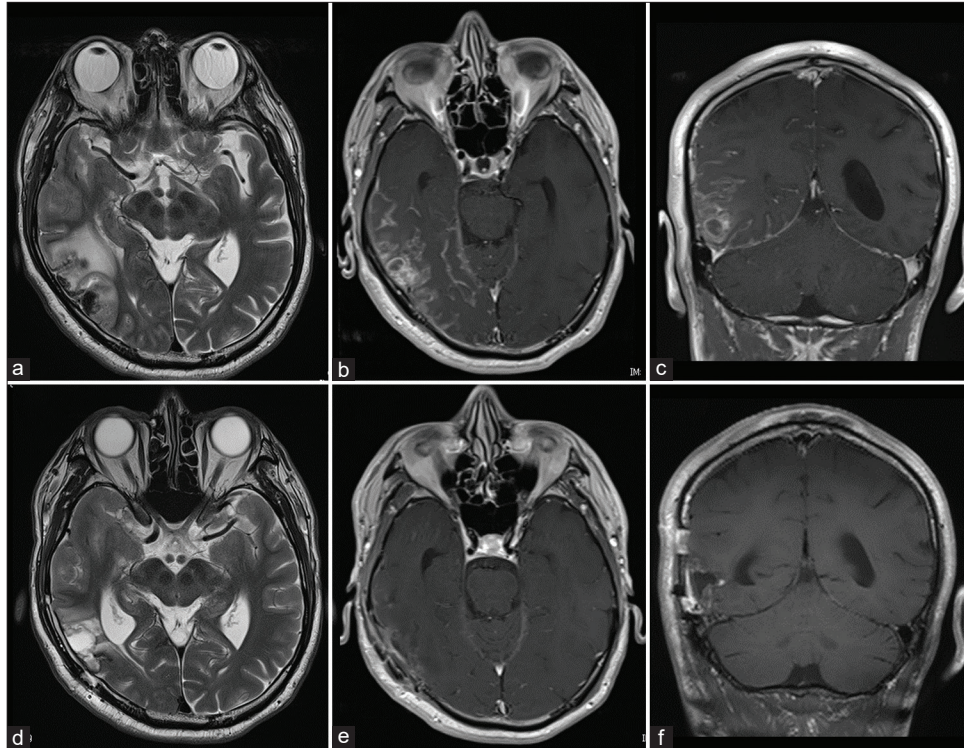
MRI findings indicative of brain metastasis. Pretreatment MRI T2-weighted image showing brain metastasis with perifocal edema in the right inferior temporal gyrus. (a) Preoperative enhanced MRI image showing brain metastasis with dissemination. (b and c) Posttreatment MRI showing shrinkage of the brain metastasis after the administration of the TKI osimertinib. (d: T2-weighted scans, e and f: enhanced MRI scan).
